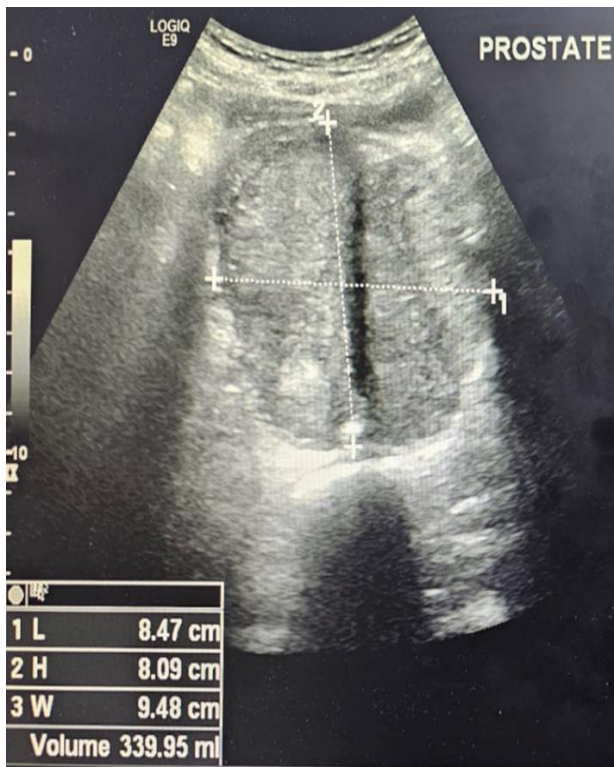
Enormous prostate in ultrasonography
